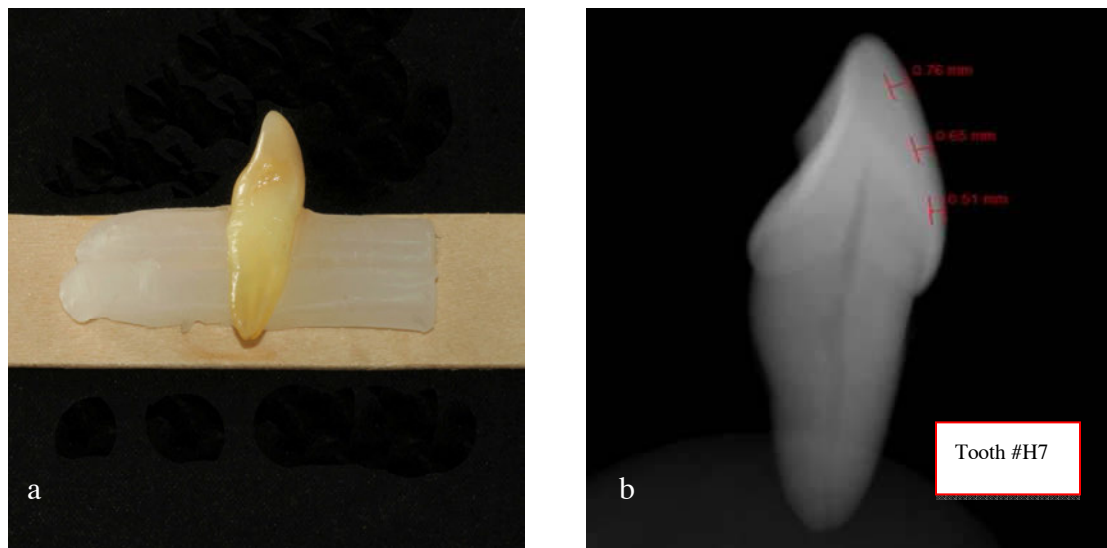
Radiographs to determine enamel thickness.
